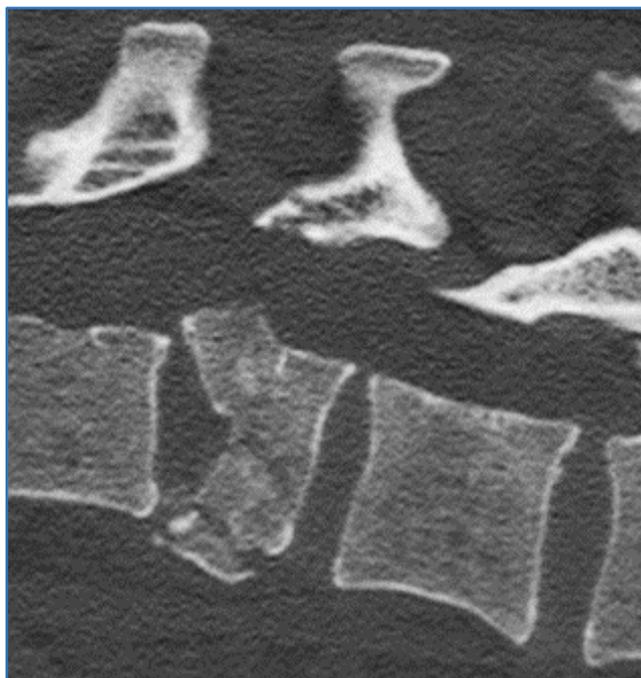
Sagittal Section of CT Showing Fracture Spine with Fragment Displaced Into Canal
